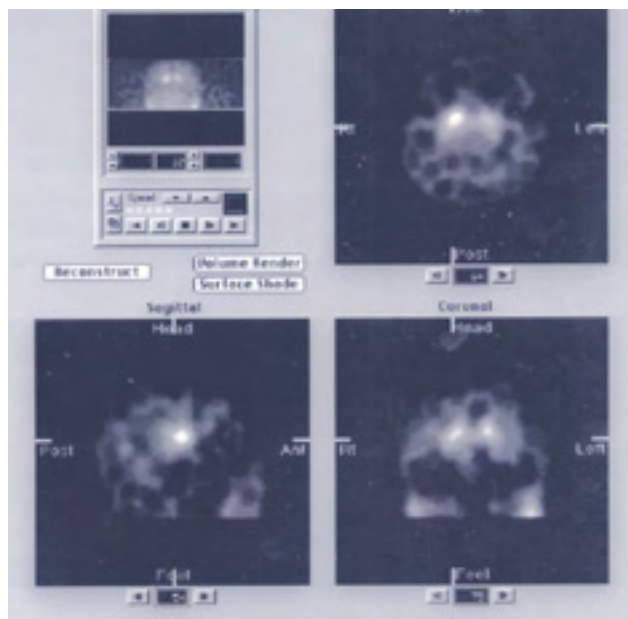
Patient No 12 with mild TRAP symptoms on the right body-side; SPECT ^{123}I -ioflupane showed an asymmetric nigro-striatal area image with decreased uptake of the tracer in the left side. $\text{RNS}/\text{Occ}=2.841$, $\text{LNS}/\text{Occ}=1.601$ and $\text{PDANS}/\text{NNS}=0.65$; a low pass cosine filter with normalized cut-off frequency of 0.35. Clinical and scintigraphic diagnosis of PD with loss of dopamine transporters in the left nigro-striatal area.
